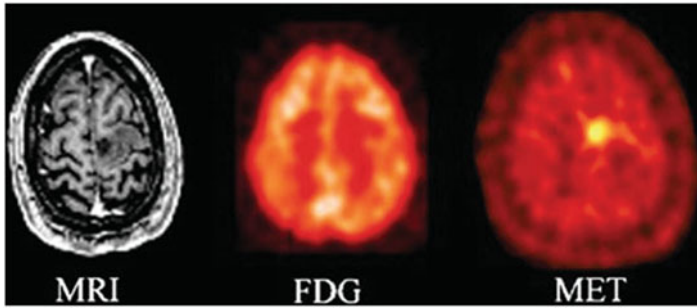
Contrast-enhanced T1-weighted magnetic resonance imaging (MRI; left), coregistered images of [F-18] fluorodeoxyglucose (FDG; centre) and [C-11] methionine (MET; right) PET in a case of low-grade (grade II) glioma. No contrast enhancement on MRI and no FDG uptake are seen, but significant increased methionine uptake is present in the same area. Amino acid PET (e.g. MET-PET, FET-PET) imaging can aid in tumour identification and tumour margin delineation in such cases. (Reprinted with permission from Singhal et al. [114])
